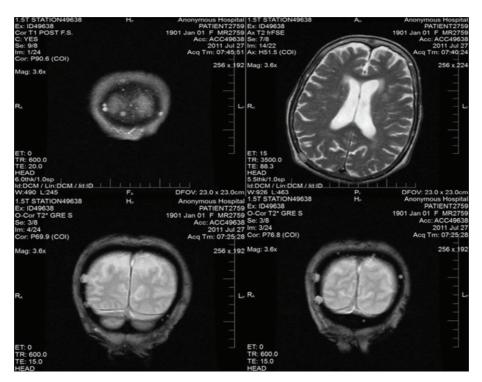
MRI demonstrating lytic lesions.
